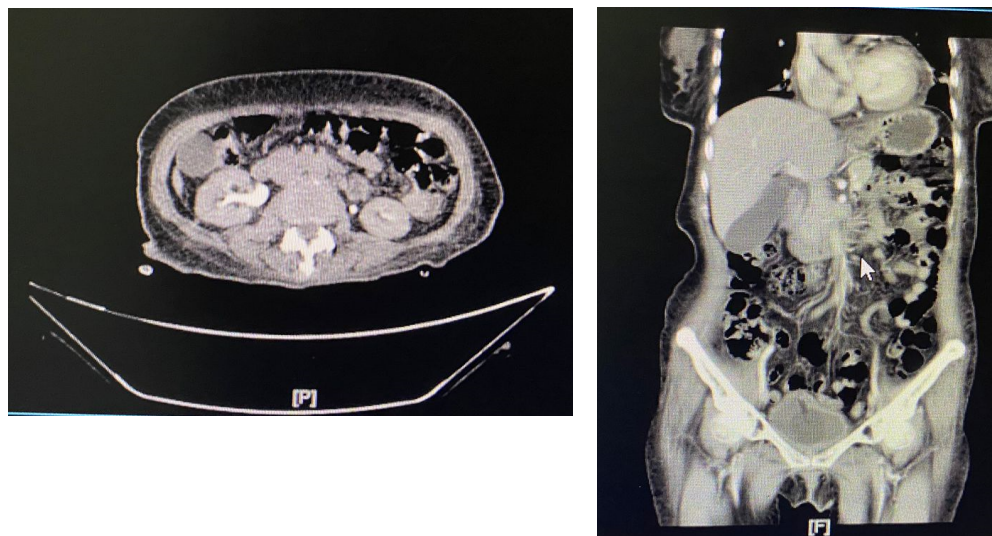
Computed tomography scan of the patient's abdomen showing hypertrophy and calcification of the right adrenal gland: (a) axial view and (b) coronal view.
